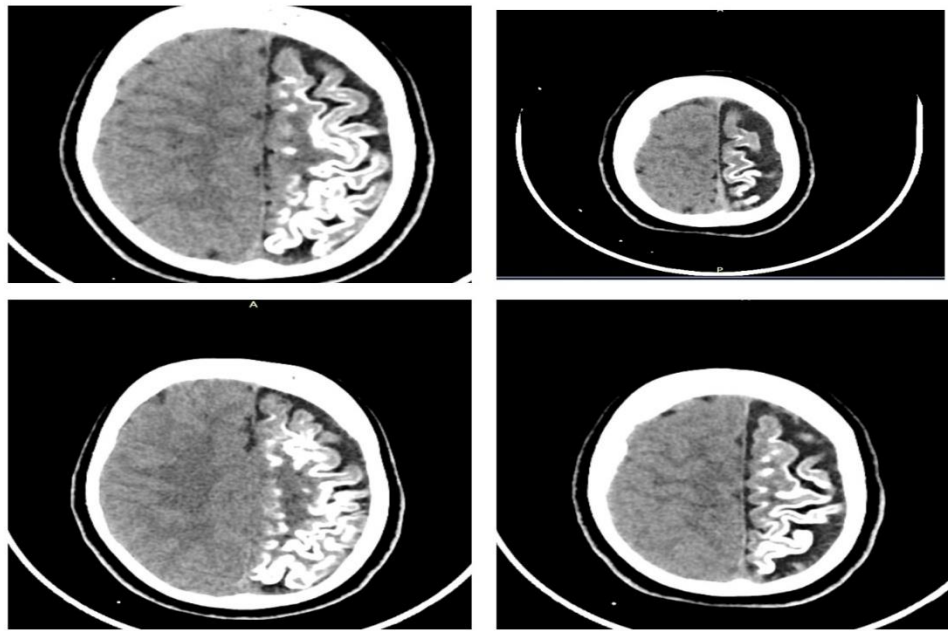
non-contrast CT scan showing left cerebral cortical atrophy with tram-track gyriform calcifications, predominantly in the parietal and occipital lobes.
